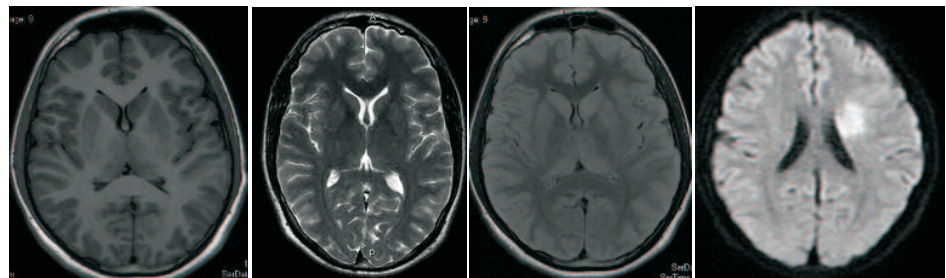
(a) T1WI (b) T2WI (c) FLAIR (d) DWI
